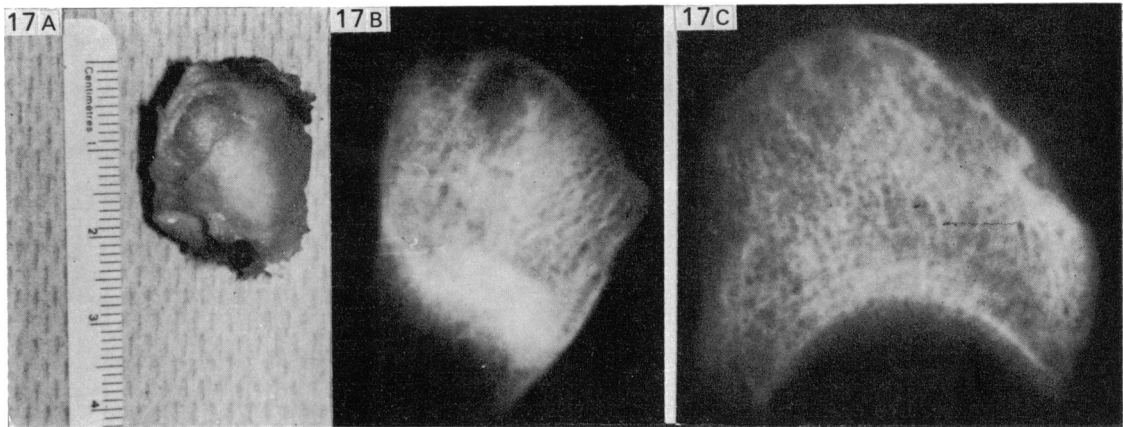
(A). Lunate bone obtained from a subject aged 63 years; there is profound ulceration on the discal half of the bone. (B) Antero-posterior and (C) lateral radiographs of the same bone showing the radiographic appearance of the ulceration.
